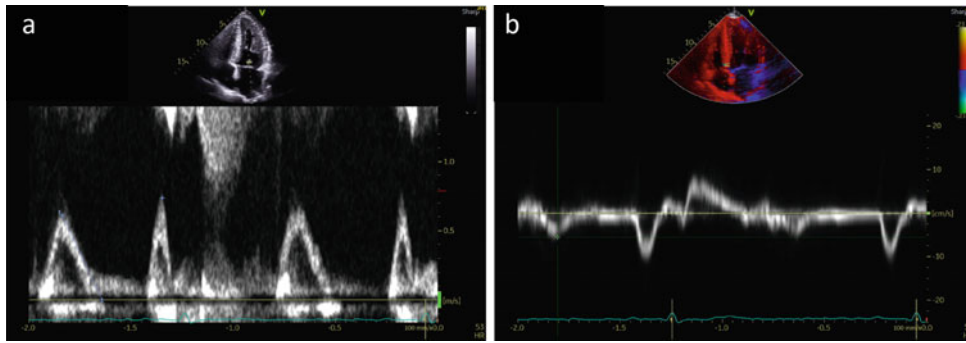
a Pulsed wave Doppler of the mitral valve. Mitral E/A ratio 0.83. b Tissue Doppler $E' = 6$ cm/sec mitral $E/e' = 8.5$; lateral $E/e' = 6.8$. Abnormal relaxation with normal LV filling pressure
